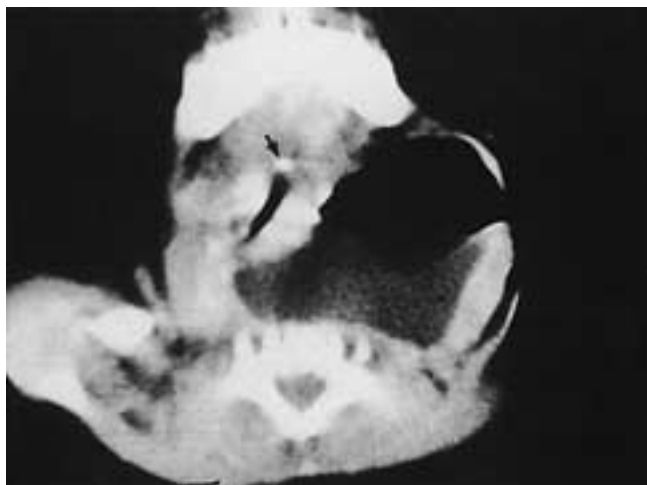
External laryngocele. This full-term infant developed a neck mass and respiratory distress within the first week of life. Axial CT scan shows a large left neck mass with an air-fluid level and compression of the airway at the level of the hyoid bone (arrow).
